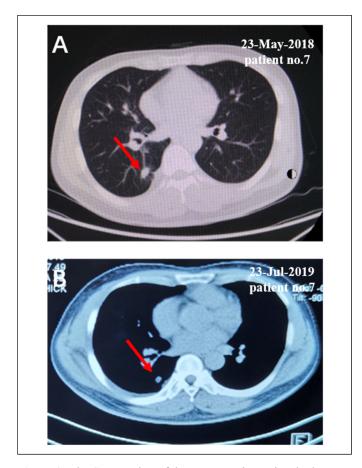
The CT scan data of the representative patient in the gefitinib/NKT arm after being treated with NKT-cell. The CT scan results at (A) the baseline and (B) three one-cell-therapy-cycles NKT cell treatment (Count up to 24 times NKT cells adaptive transfer in total 60 weeks) were shown.
